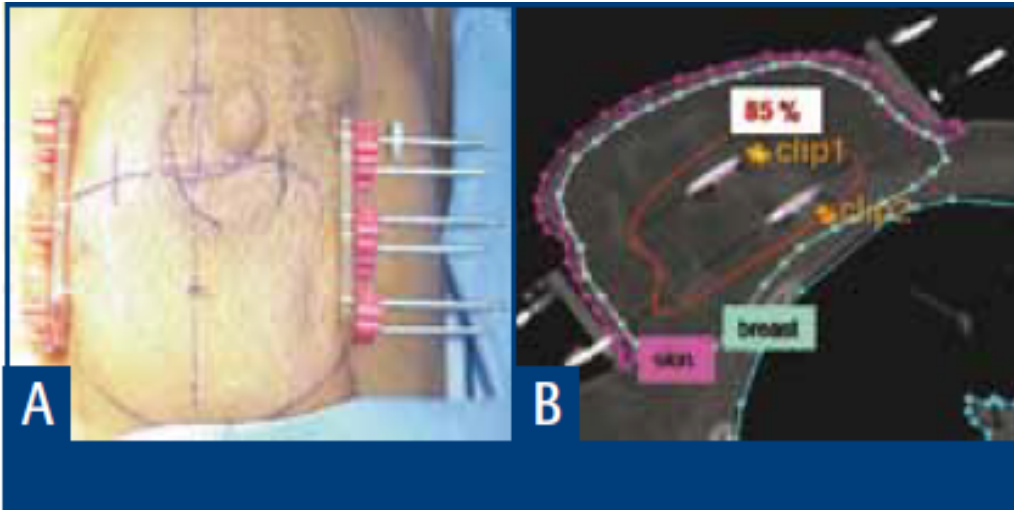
Multicatheter interstitial brachytherapy. A: External appearance of the implant. B: Transversal CT slice with an indication of the 85% isodose (—), at a large distance from the skin (Erven *et al.*, 2008).
